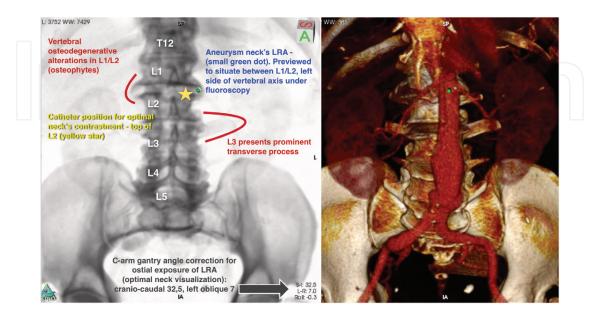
The complete "beyond basics" study of CTA.
